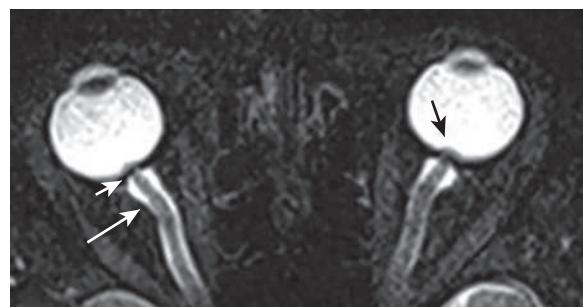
Papilledema. Axial T2-weighted image with fat saturation of the orbits shows enlargement of the optic nerve sheaths (long white arrow), flattening of the posterior sclera (short white arrow), and protrusion of the optic disc head into the globe (black arrow). (Modified from Guarnizo A, Albreki D, Cruz JP, et al. Papilledema: a review of the pathophysiology, imaging findings, and mimics. Can Assoc Radiol J. 2022;73[3]:557–567, Fig. 3a, p.561.)
